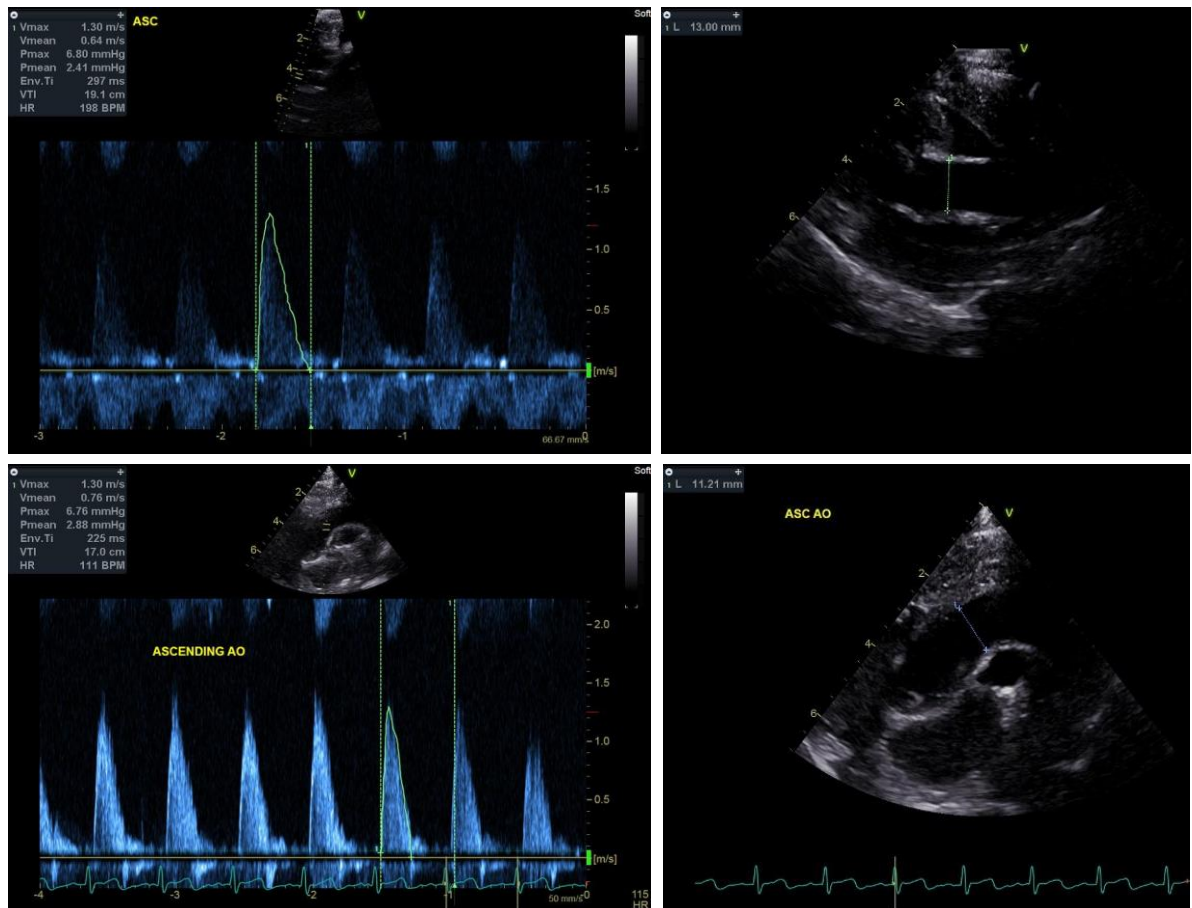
Ascending aorta echocardiography results for both pre- (top row) and post- intervention (bottom row) instances
